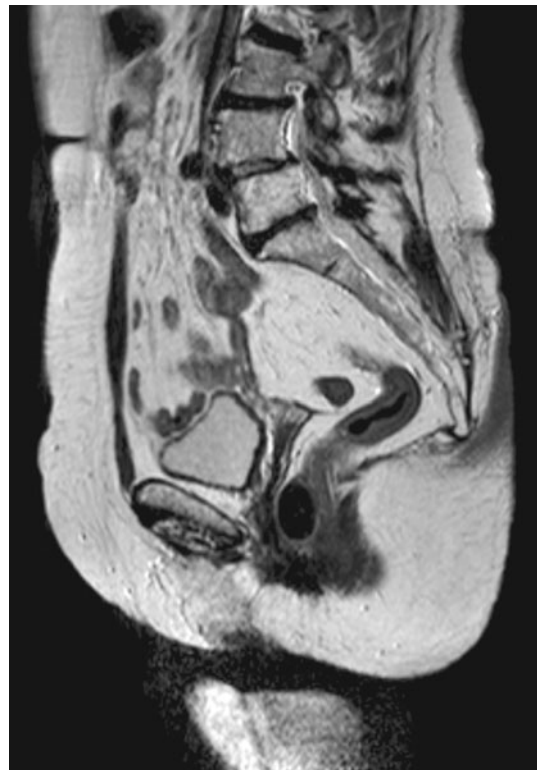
Sagittal MRI showed the mass was enclosed in rectal mucosa at the level of the rectovaginal septum
